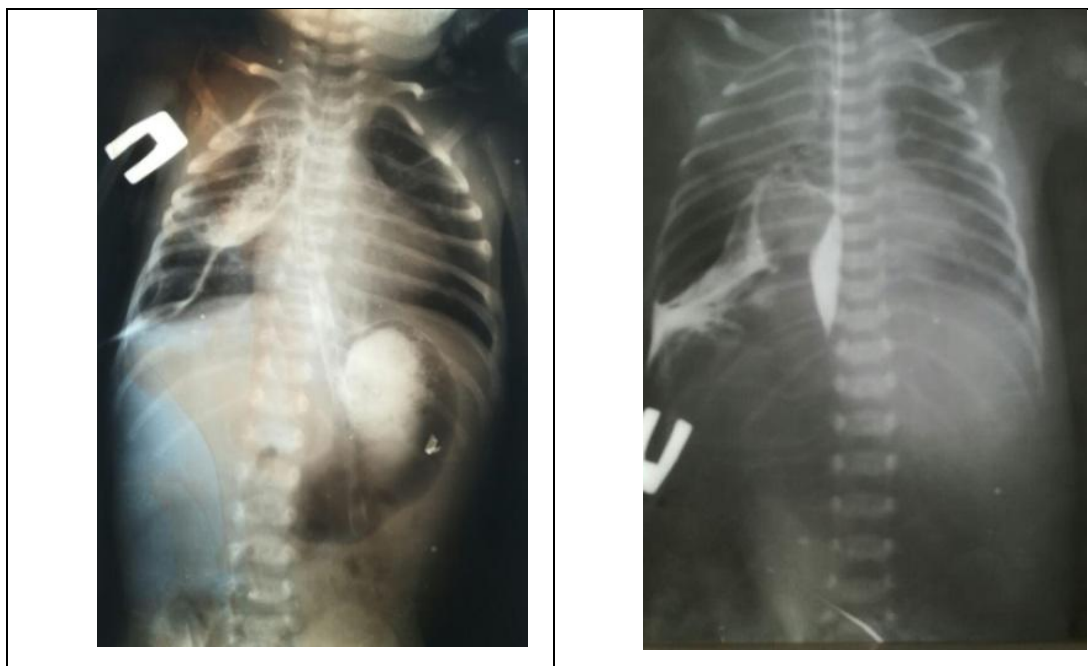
1. Radiograph of anastomotic leak in esophageal atresia
